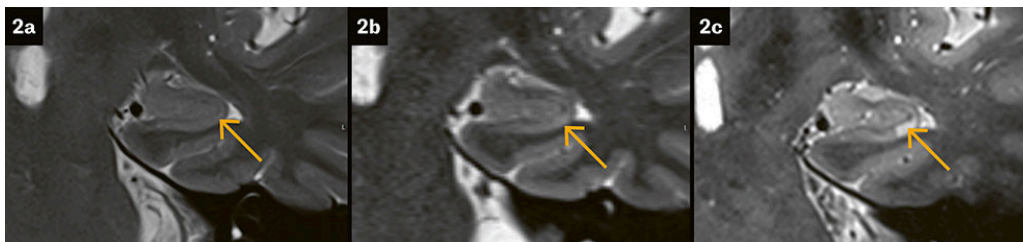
Hyperintense punctate lesion in the left hippocampus in transient global amnesia (arrow). T2-weighted sequences in the coronal plane, taken with the following MRI field strengths: 1.5 T (a), 3 T (b) and 7 T (c). Higher field strengths improve conspicuity of the lesion (1.5 T: not visible, 3 T: barely visible, 7 T: clearly visible).
